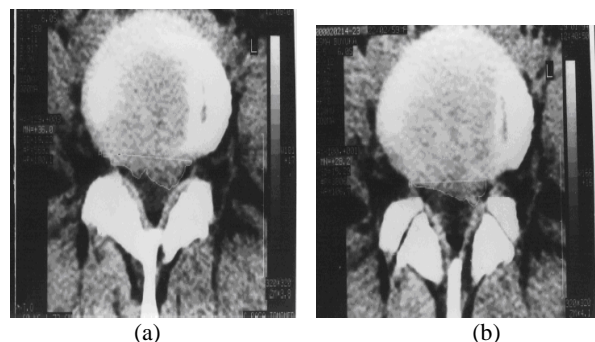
(a) CT-scan before traction, showing the median disc herniation at L4-L5. Herniated nuclear material invades the spinal canal and left neural foramina and, compresses the dural sack and L5 nerve root. Spinal canal area and neural foramina are narrowed; (b) CT-scan during traction using 45 kg of force. Regression of the nuclear material from the discal space and neural foramina can be seen. Neural foraminal diameter and spinal canal area are increased (Reprinted with permission [26]).
